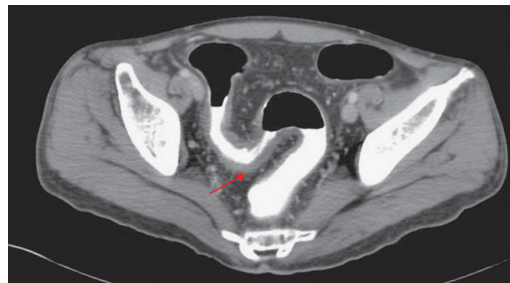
CT demonstrating circumferential mural thickening and hyperemia, consistent with pancolitis.
